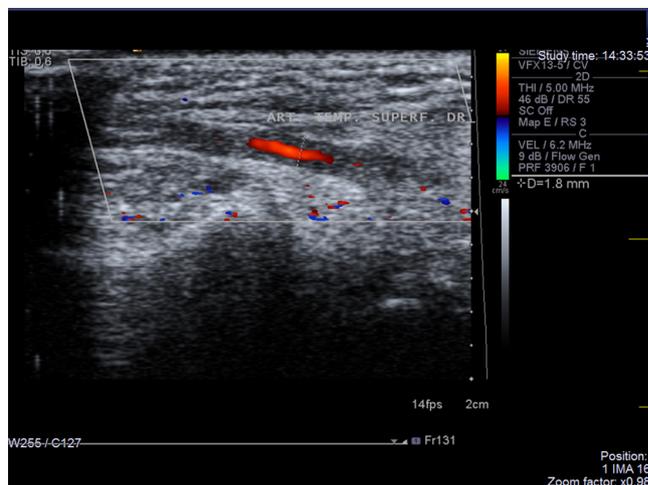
Case 1. Temporal arteritis in a 80-year-old woman. Colour duplex ultrasound examination of the temporal artery, longitudinal section, showing pronounced hypoechoic mural thickening ('halo sign').
